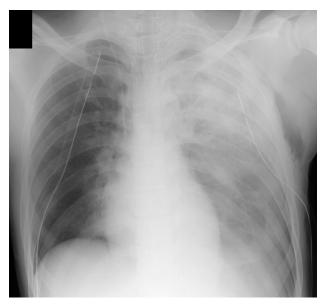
Plain chest roentgenogram obtained in the supine position 50 minutes after arrival. The left upper lobe is moderately collapsed, and a severe infiltrative shadow is seen. There is decreased radiolucency in the left thoracic cavity, reflecting a large volume of intrathoracic hemorrhage. Chest tubes are inserted in both sides.
